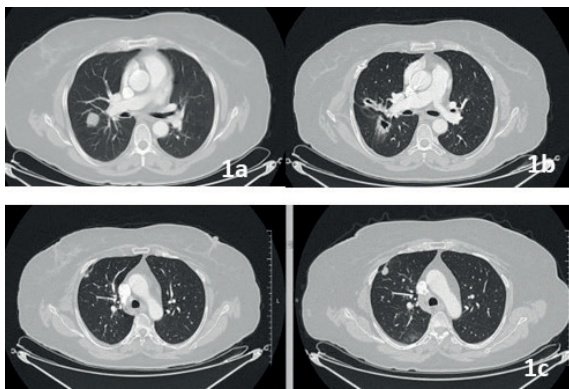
a: 22x23 mm nodule in the middle lobe of the right lung on the thorax CT, b: Cavity lesions on the thorax CT, c: Progression of the peripheral nodule in the right upper lobe on the thorax CT.
